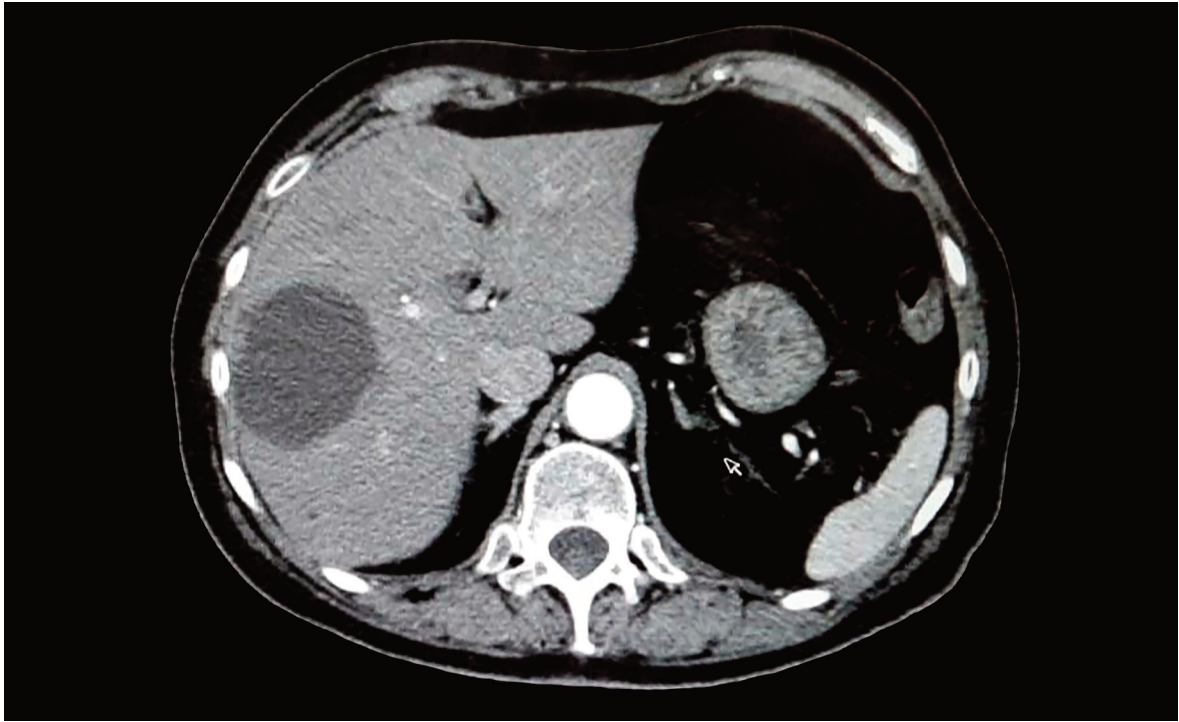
Computed Tomography (CT) image: simple liver cysts.
